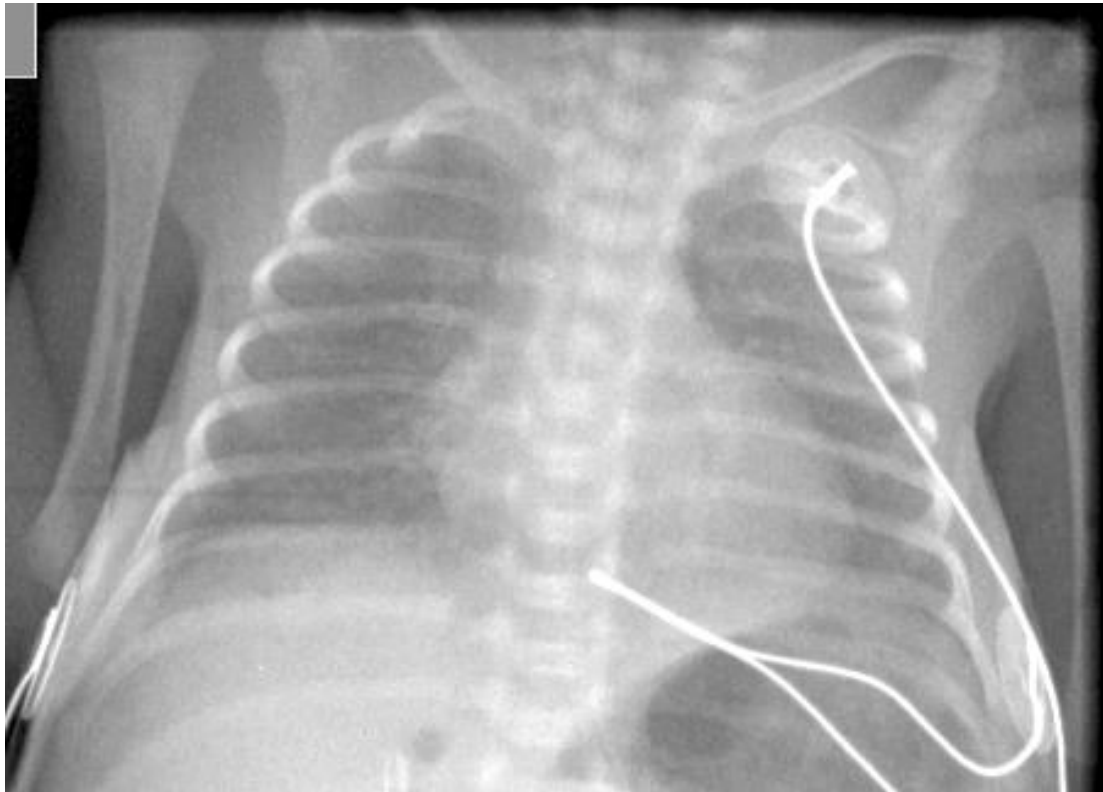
1,6 mA s exposure X-ray with correct rotation, in which evaluation of the mediastinal border is possible
